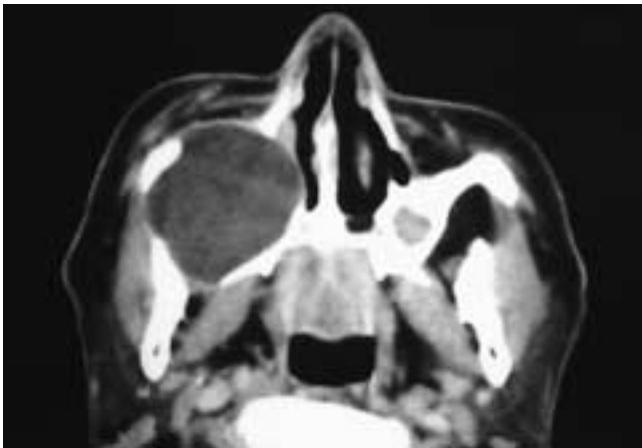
Axial CT scan shows a large, expansile mucoid attenuation right maxillary sinus mass. Portions of the bony wall are thinned. This patient had a right maxillary sinus mucocoele.
